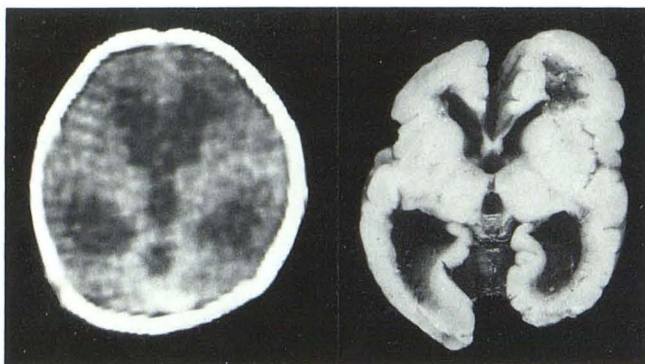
Hydrocephalus after intracranial hemorrhage, premature neonate, 29 weeks, birth weight 1,510 g. Death at 25th day from hyaline membrane disease. *CT*: enlargement of ventricular system, periventricular lucency, slight deformation of right frontal horn. *Autopsy*: posthemorrhagic hydrocephalus after intraventricular and secondary subarachnoid hemorrhage, partly resorbed right frontal intracerebral hematoma communicating with ventricle.
